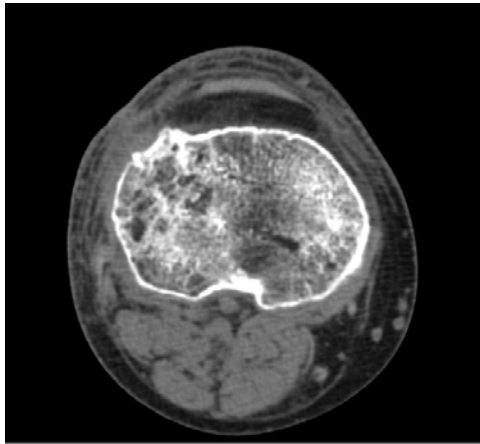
Recovery of cancellous bone structure after the repair with type 1 collagen sponge with bone chips (spiral computed tomography).
